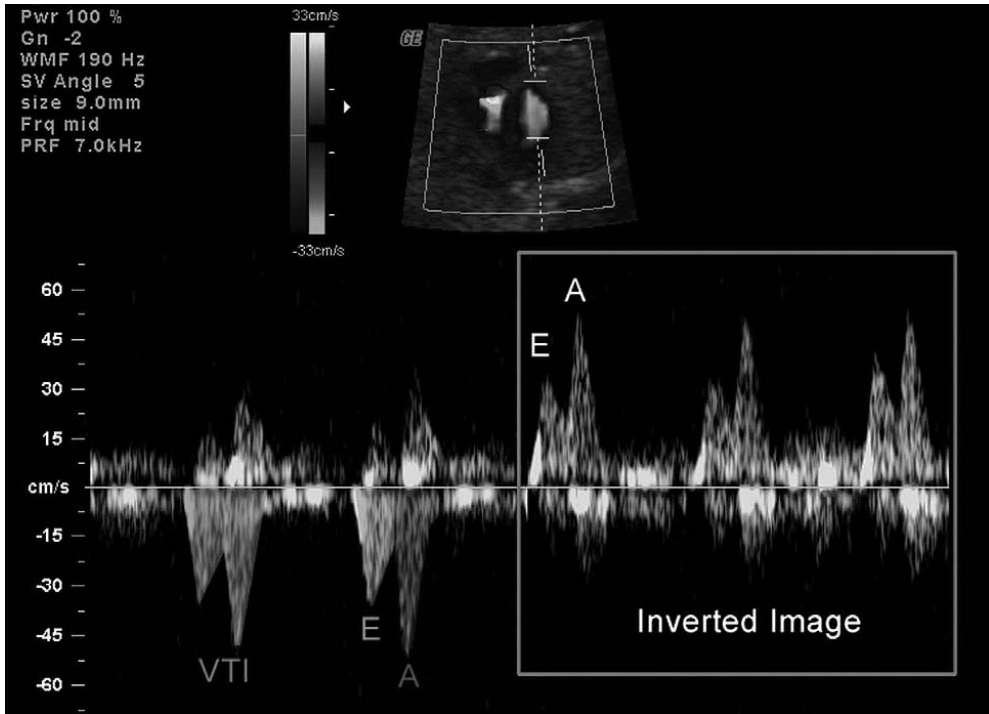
A double peaked waveform of a Doppler blood flow recording over the mitral valve. The E-wave (green), A-wave (purple) and the velocity time integral (orange) are marked. For optimal Doppler recordings the angle of insonation is kept as low as possible (in this image the angle is 5 degrees as is noted in the upper left corner; SV Angle 5). Adapted from *Seminars in Fetal & Neonatal Medicine* (2005) 10, 515-541.
